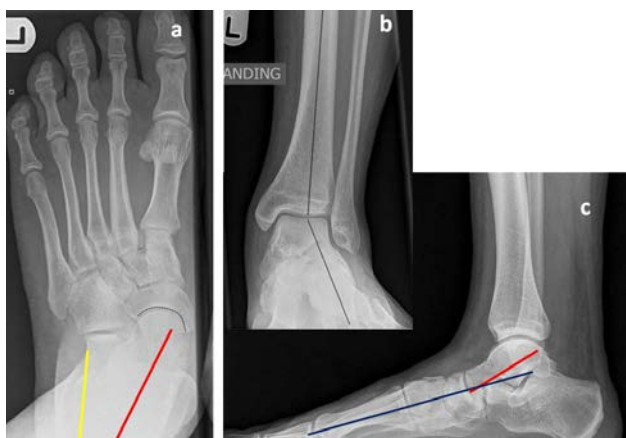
Weight bearing radiographs of a planovalgus foot. On the anteroposterior foot view (a) one can measure Kite's angle (normal if less than 25°), formed by the intersection of a line bisecting the head of the talus (red line), and a line that crosses parallel to the calcaneus (yellow line). In this occasion the talonavicular joint remains congruent. On the ankle anteroposterior view (b), one can assess the increased valgus of the heel in relation to the tibial axis (black lines). On the lateral foot view (c), the Meary's angle is measured, formed by axis of the talus (red line) and the first metatarsal (blue line). It should be zero (talus and first metatarsal axis parallel) in normal feet.
